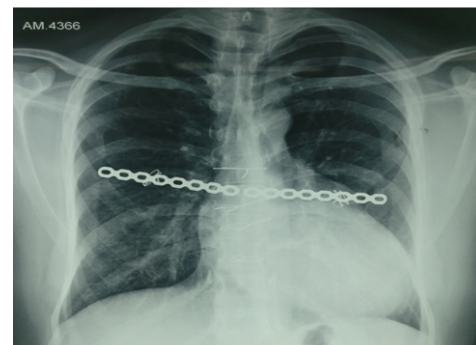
Pre-operative radiograph showing sternal wires and chest reconstruction plate from previous Bentall's procedure and chest wall reconstruction surgery.
